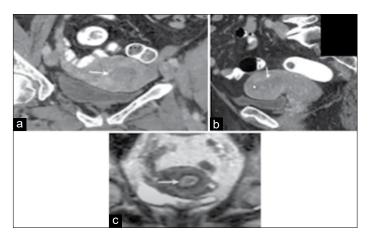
CT scan. (a) In transverse section shows endometrium. (b) Sagittal section with endometrium showing no breach of endo-myometrial junction. (c) MRI showing endometrial junction with localized
